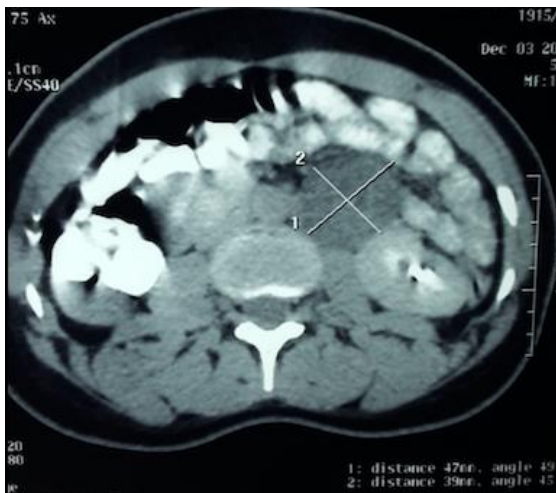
CT scan: retroperitoneal, left pre renal mass with tissue density (32 HU), measuring 47 mm long axis
